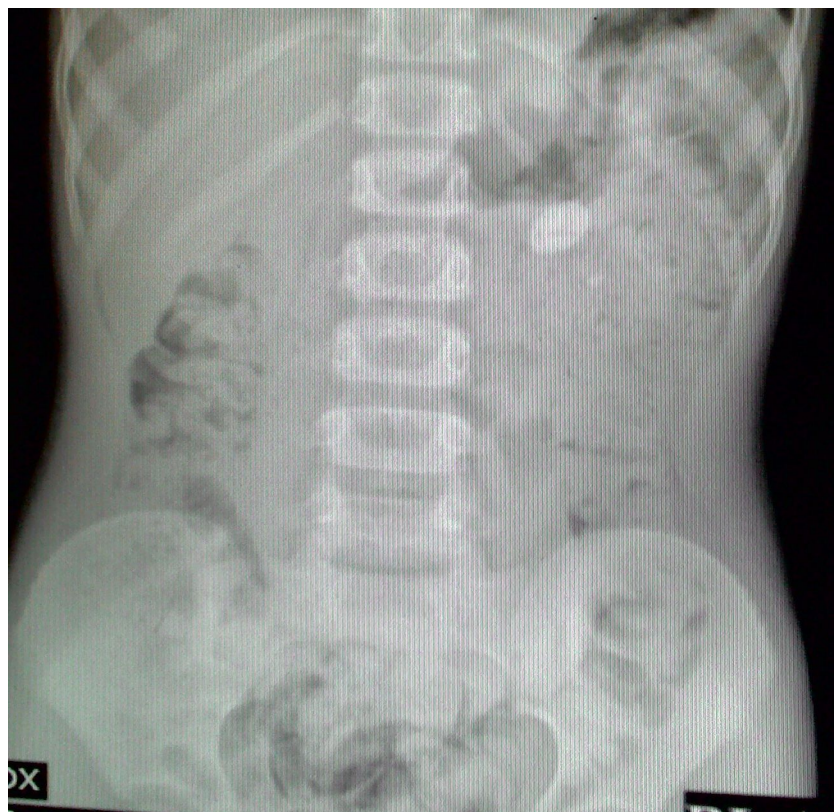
Plain Xray showing left side renal calculus in a 8 year old boy
